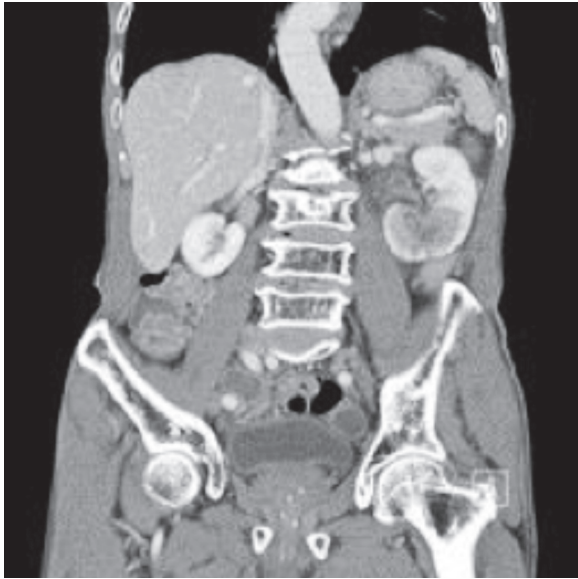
Initial finding on computed tomography. CT scan revealed left renal pelvis and ureteral wall thickening with enhancement and mild hydronephrosis with multifocal wedge-shaped low enhanced lesions on Lt renal lower pole.
